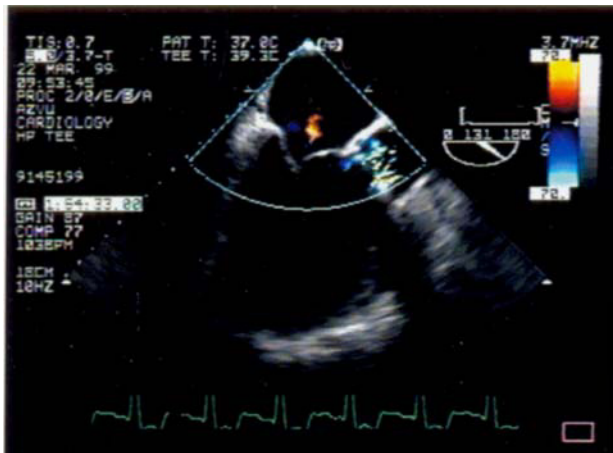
Transoesophageal echocardiographic colour flow image of a Duromedics prosthetic valve in the aortic position (systolic frame). The two tilting discs of this bileaflet valve prosthesis can clearly be observed.
